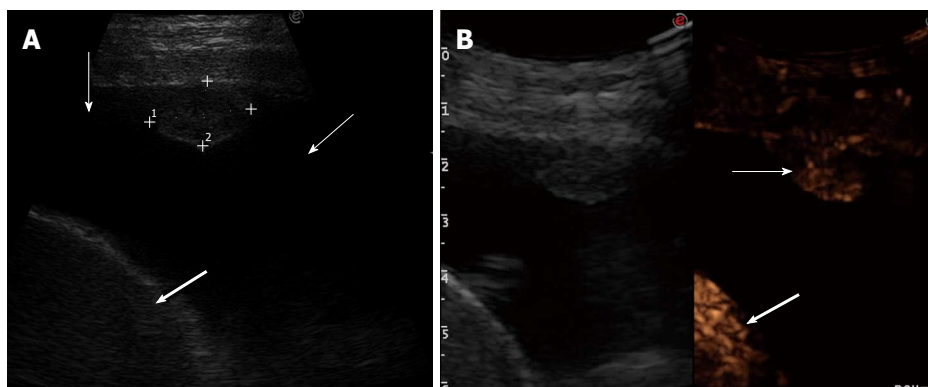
Delayed arterial enhancement. A: Transverse sonogram of the left chest wall in the seventh intercostal space along the mid-axillary line showing an isoechoic pleural nodule, pleural effusion (thin arrows), and spleen (large arrow); B: Transverse contrast-enhanced sonogram in the arterial phase showing inhomogeneous enhancement of the nodule (thin arrow) that occurs contemporaneously to the enhancement of the spleen (large arrow) (left side of the split-screen); the enhancement of the nodule is less marked than that of the spleen. Final diagnosis was pleural metastasis from colon cancer.
